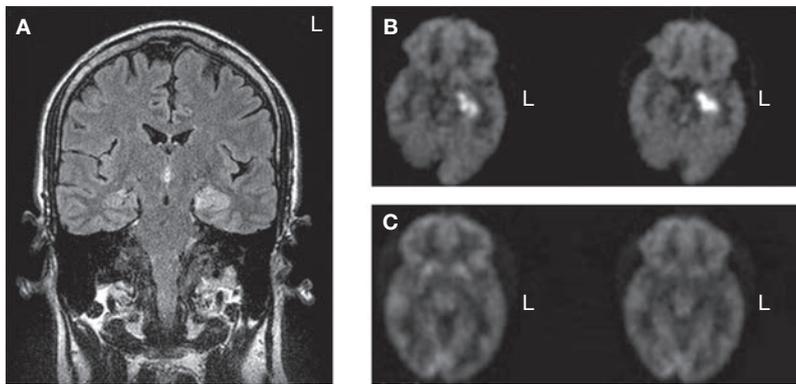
Brain scans from a patient with transient epileptic amnesia. (A) Fluid-attenuated inversion-recovery MRI scanning during a prolonged amnesic episode reveals hyperintensity in the left hippocampus. (B) 2-Fluoro-2-[^{18}F]-deoxy-D-glucose PET scanning during the same episode shows hypermetabolism localized to the left anterior hippocampus. (C) Metabolism in the left anterior hippocampus returned to normal 1 month later. Abbreviation: L, left.
